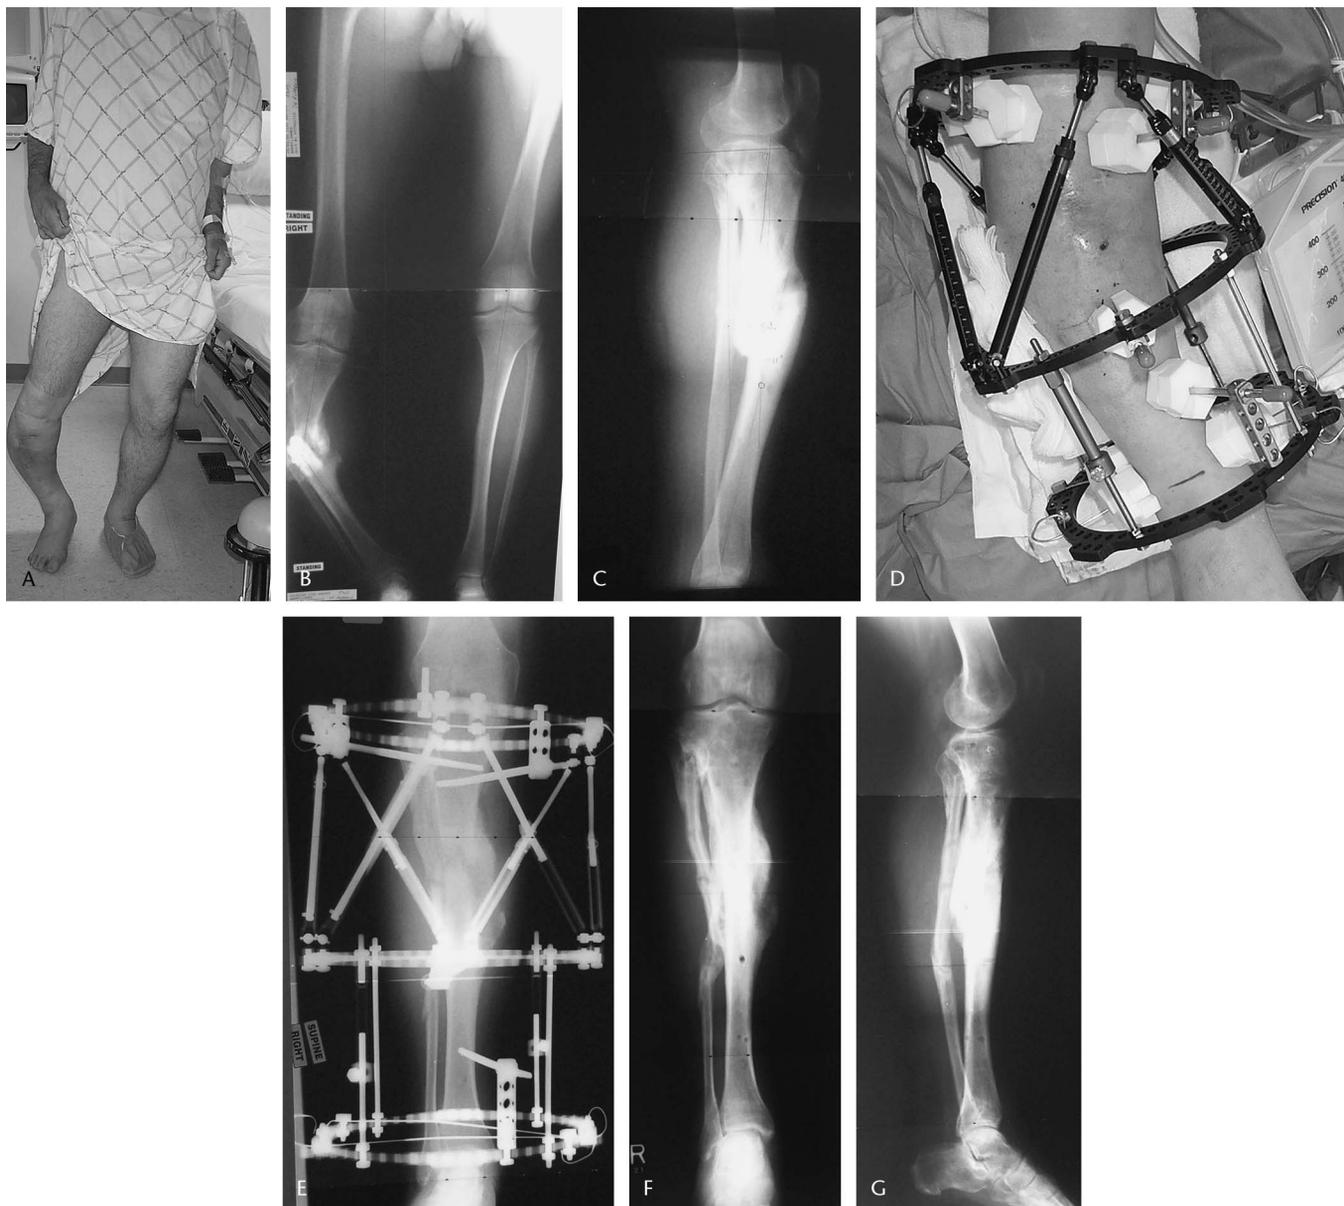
A, B, C, Preoperative front view, anteroposterior (AP), and lateral radiographs showing a hypertrophic tibia nonunion with deformity and shortening. D, Immediate postoperative front view showing Ilizarov/Taylor Spatial Frame in place matching the deformity. E, AP radiograph 5 weeks after surgery and distraction of the nonunion. Note that neither osteotomy nor open approach was performed. F, G, AP, lateral radiograph, and front clinical view at 6 months after surgery showing bony union and correction of deformity.
